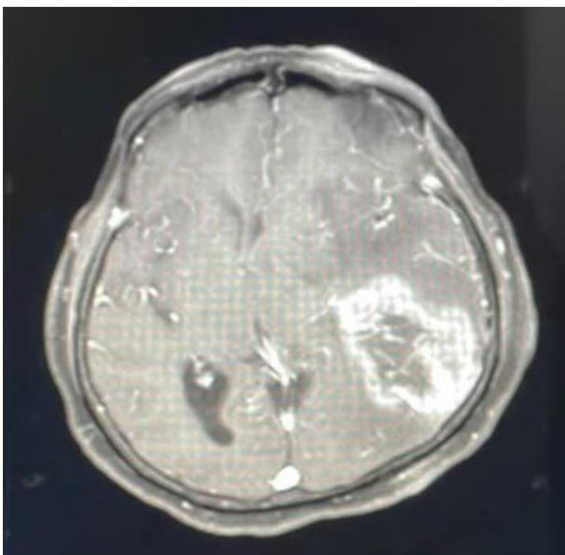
Axial T1 post contrast image of MRI brain shows a lesion predominantly in the left parietal region with thick irregular ring enhancement, perilesional edema and mass effect-glioblastoma multiforme.
